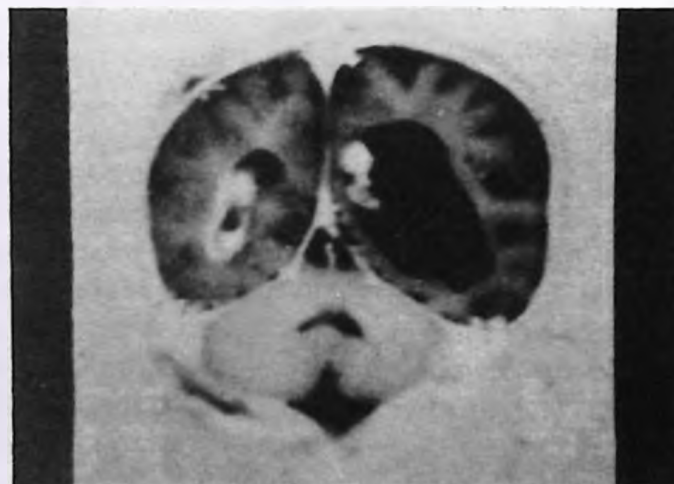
Cranial MRI showing marked dilatation of left lateral ventricle and choroid plexus hemorrhage in both ventricles. White matter is decreased on both sides (Note. The superior sagittal sinus is hyperintense due to postmortem imaging) (Case 1).
